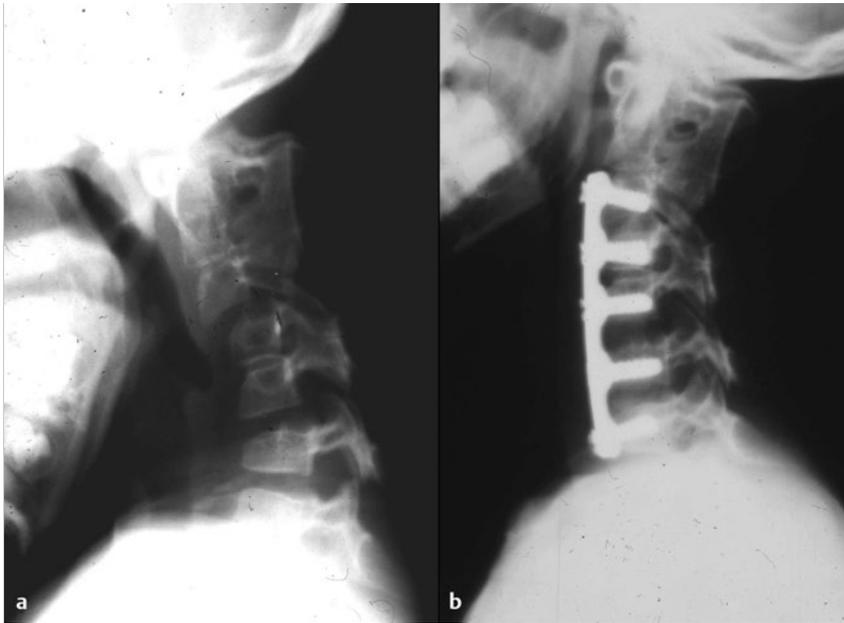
A 9-year-old girl presented with Klippel-Feil syndrome. (a) Plain lateral cervical spine radiograph in flexion reveals significant subluxation at the C4–5 and C6–7 levels. (b) Postoperative lateral radiograph demonstrates multilevel anterior cervical discectomy and fusion with plating. The patient went on to have a successful fusion.
